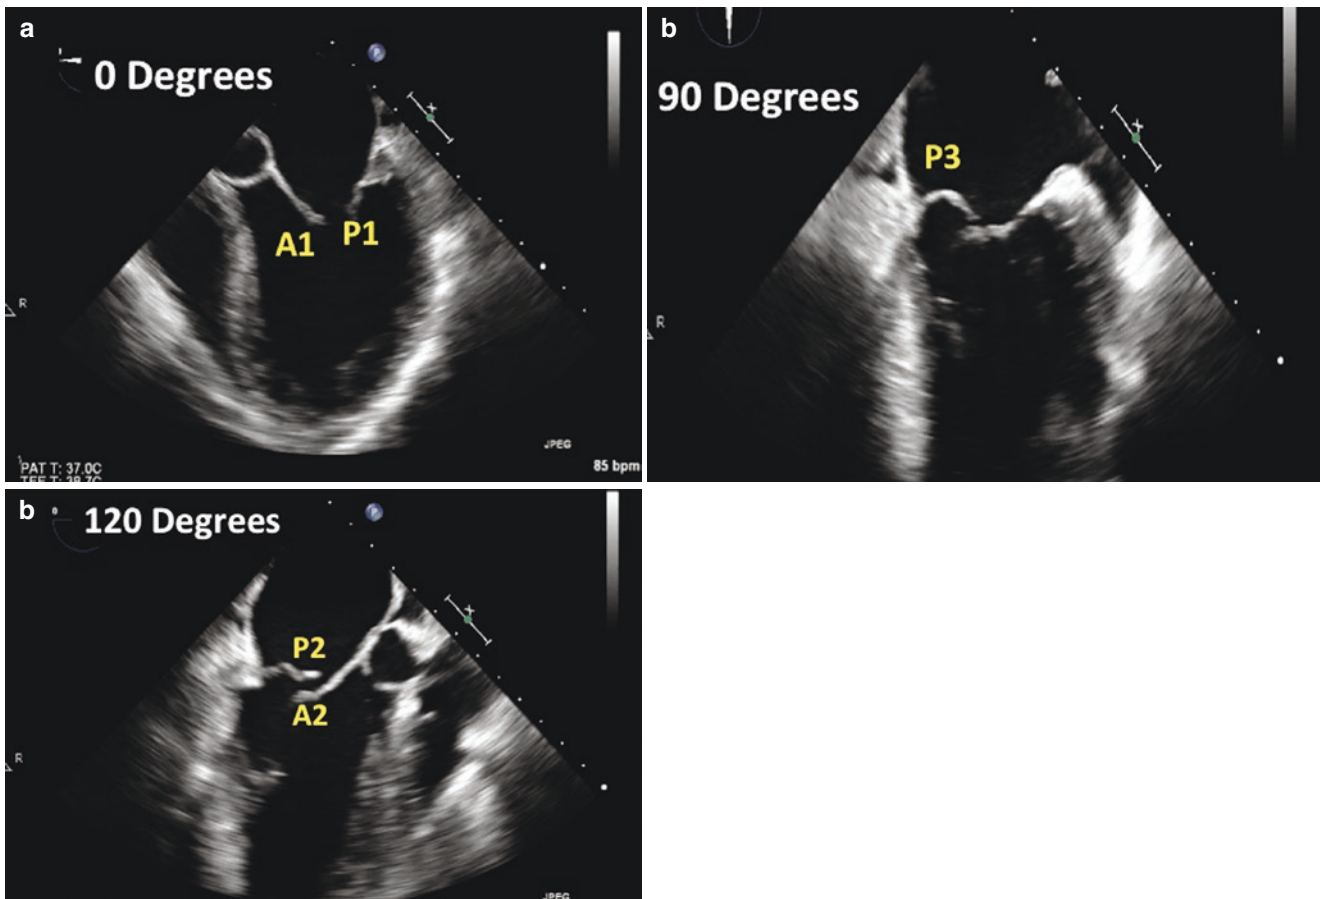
Transesophageal echocardiogram (TEE) demonstrating the different mitral scallops. Panel a: at 0°, A1 and P1 scallops are seen in the high esophageal view with the left ventricular outflow tract in view.
